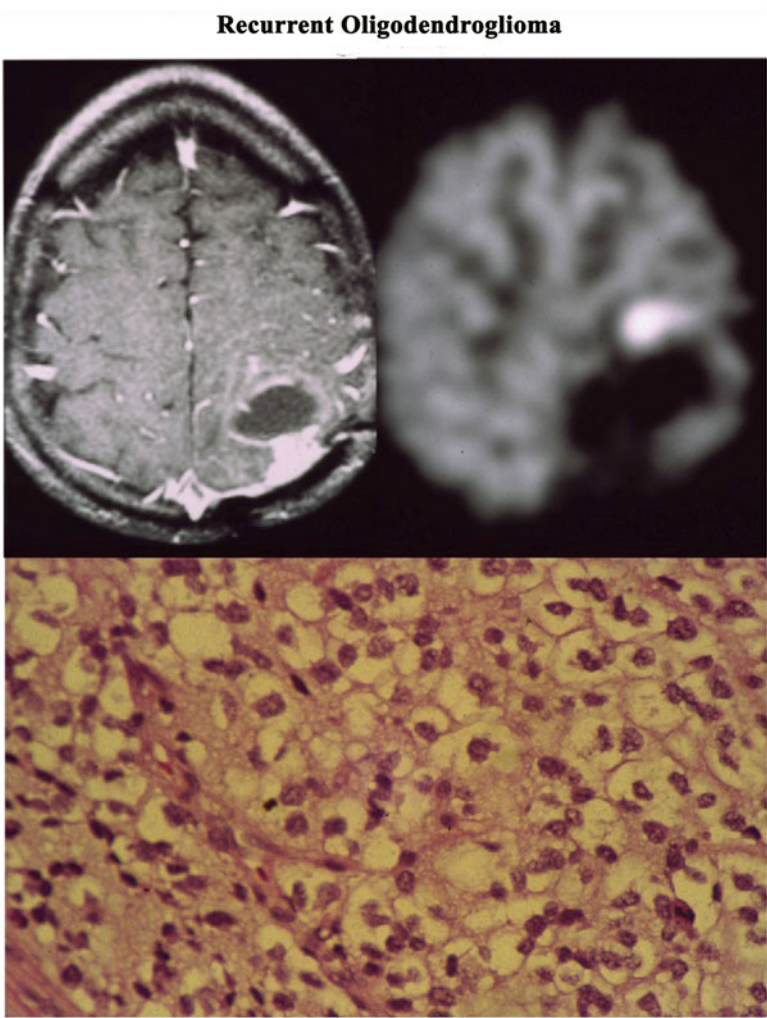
Routine surveillance follow-up contrast-enhanced CT examination was indeterminant for radiation necrosis versus recurrent tumor; PET imaging suggested
